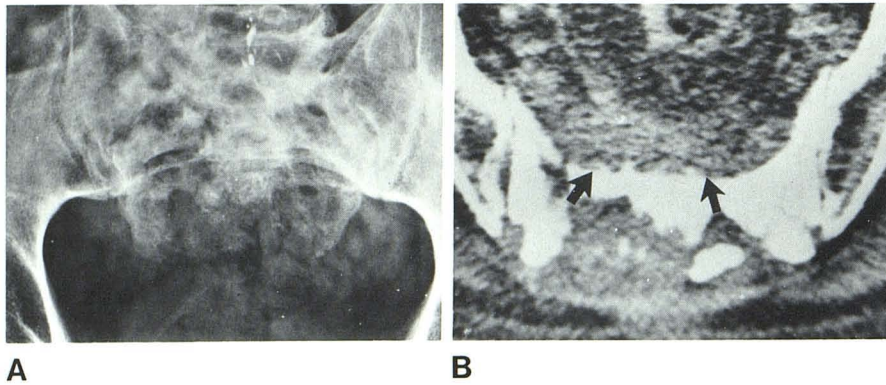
Chordoma. A, Plain film demonstrates extensive destruction of sacrum. B, CT confirms diffuse destructive pattern of bony sacrum as well as revealing ventral and dorsal soft-tissue component (arrows).
